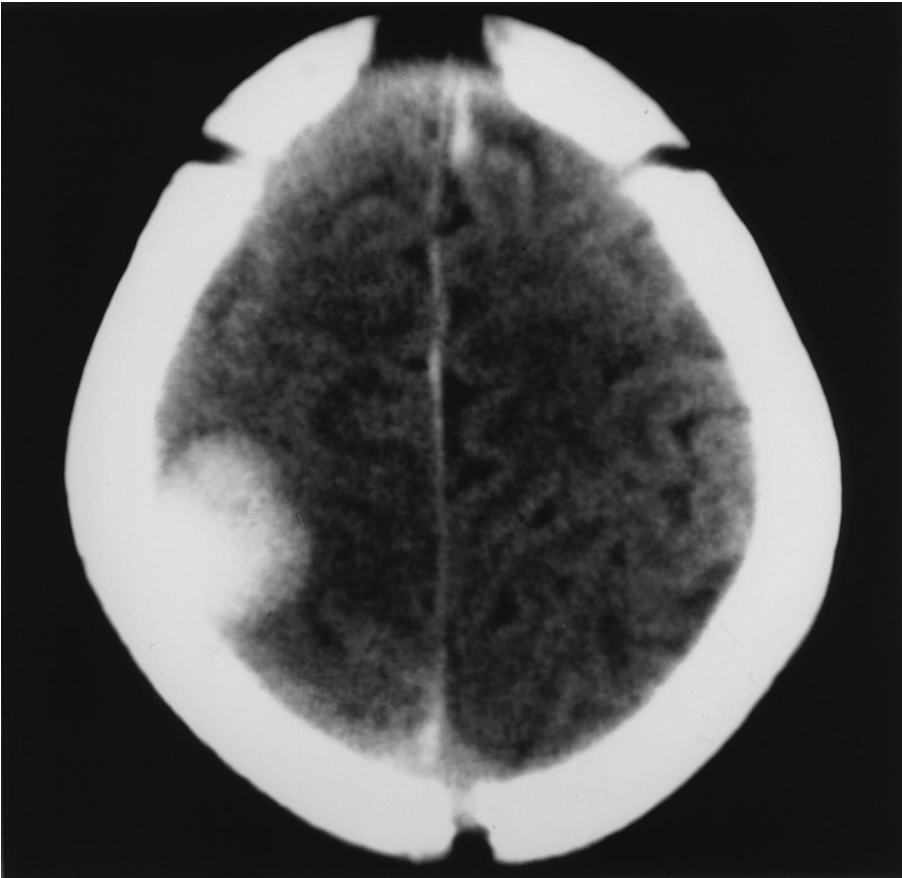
In patient 10, CT Scan revealed hemorrhagic injury in the right parietal area and a vascular malformation was suspected.
